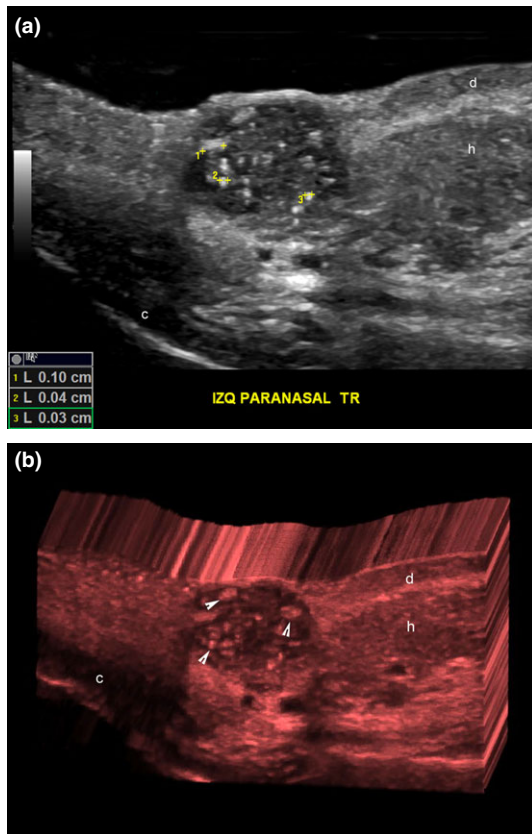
(a,b) Basal cell carcinoma ultrasound. (a): left nasal region (grey scale, transverse view) demonstrates multiple hyperechoic spots within the tumour (some marked and measured between 0.3 and 1.0 mm) and (b): left nasal region (transverse view, 3D reconstruction): multiple hyperechoic spots; some marked by arrowheads. c, nasal cartilage; d, dermis; h, hypodermis.
